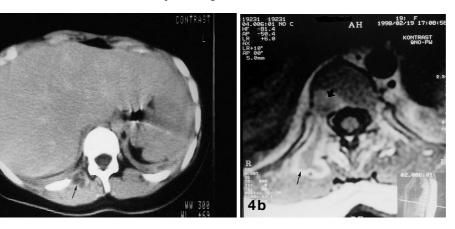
a Contrast-enhanced CT and b MR show a paraspinal mass lesion with a thick, enhancing capsule and necrotic centre (*thin arrow* in a and b). There is contiguous involvement of the adjacent vertebral body (*thick arrow* in b)
